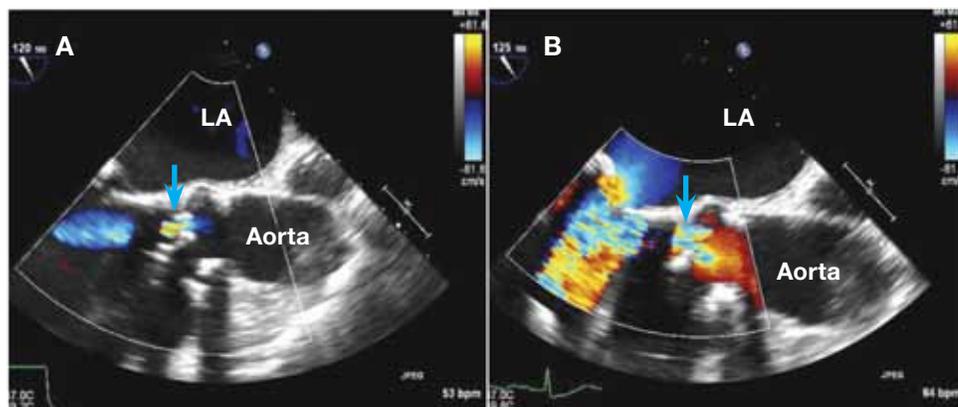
Transesophageal echocardiogram with color Doppler is used to compare severity of aortic regurgitation before (A) and after (B) balloon valvuloplasty of the aortic valve.
